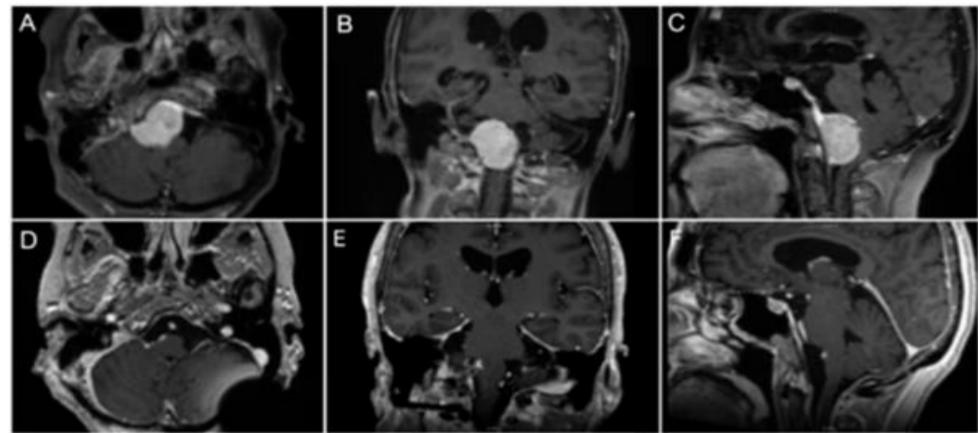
Preoperative magnetic resonance imaging (MRI) in T1 post-contrast sequences in the axial (A), coronal (B), and sagittal planes (C) demonstrates a 3.5cm homogeneously enhancing ventral brainstem mass with a dural tail, suggestive of a meningioma. This meningioma was gross totally resected (D-F).
